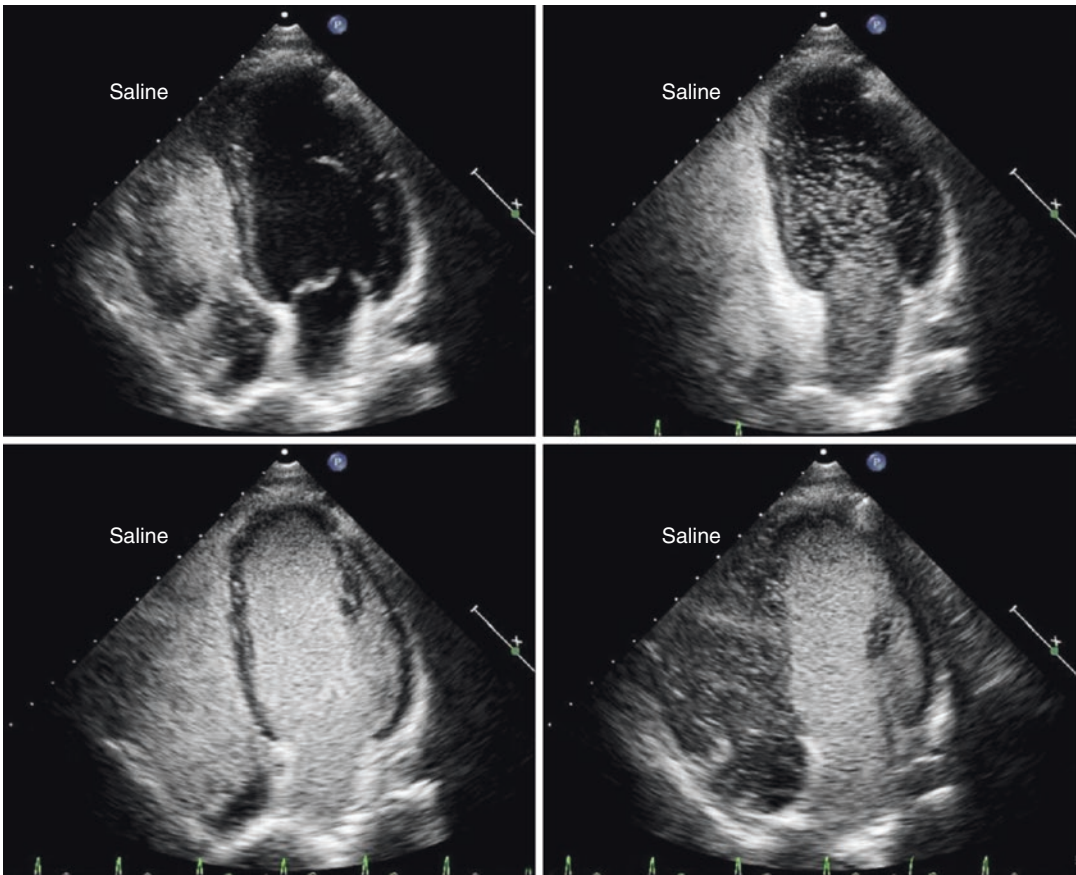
Saline Contrast Echocardiography Performed in a Patient With ESLD Revealing Marked Right-to-Left Shunt Through Pulmonary AVM. The upper left panel is immediately after appearance of contrast in right heart. The upper right panel is five beats following appearance and reveals nearly continuous flow into the LA and LV. The lower left panel is approximately 10 s after injection
